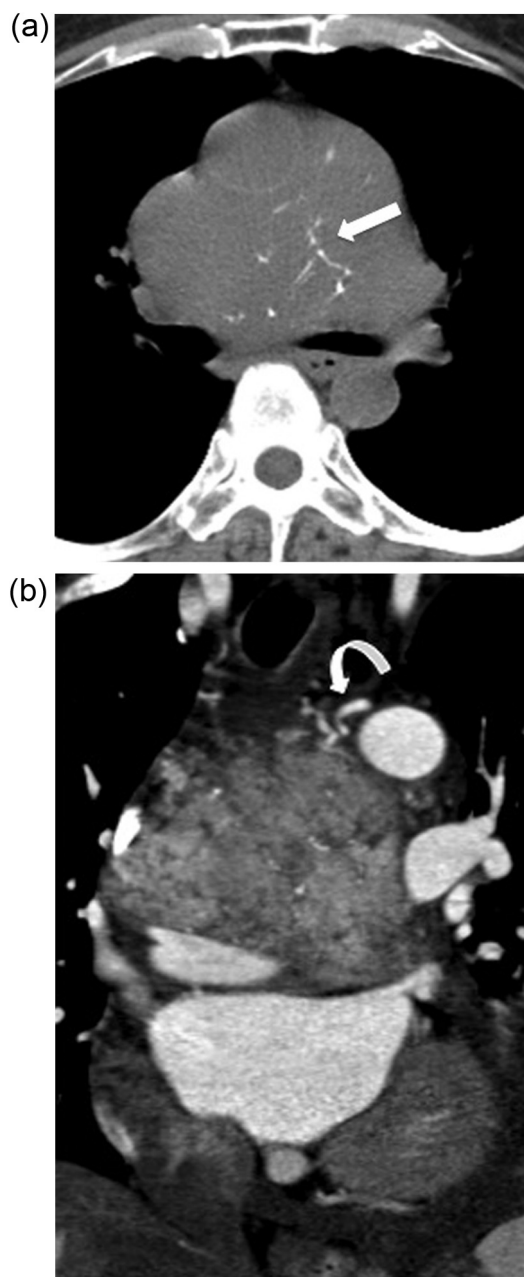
59-year-old woman with unicentric Castleman disease, hyaline subtype. (A) Unenhanced axial CT scan shows large middle mediastinal mass with central arborizing calcification (arrow). (B) Coronal contrast-enhanced CT image demonstrates intense enhancement within the mass which appears to compress and displace the pulmonary arteries and abuts the aortic arch. Multiple feeding vessels are noted in its periphery (curved arrow) due to the significant vascularity. Video-assisted thoracoscopic surgery (VATS) biopsy was performed, resection was not feasible due to the extreme vascularity.
